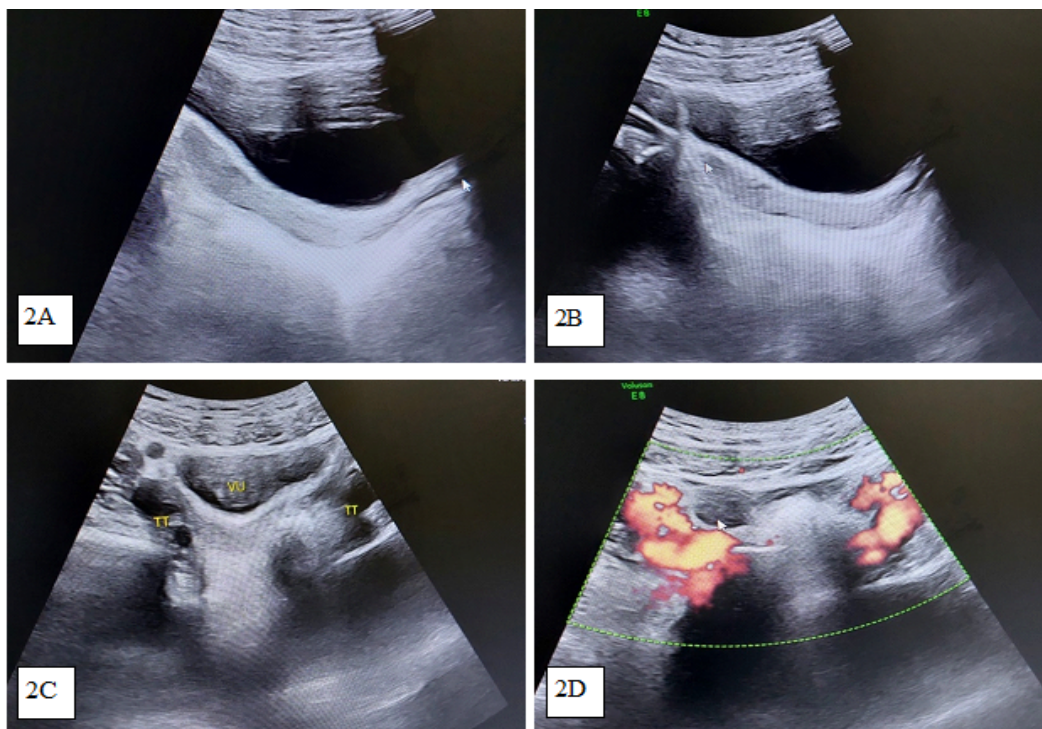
Ultrasonographic findings: unclear image of the uterus, fallopian tubes, and cervix
